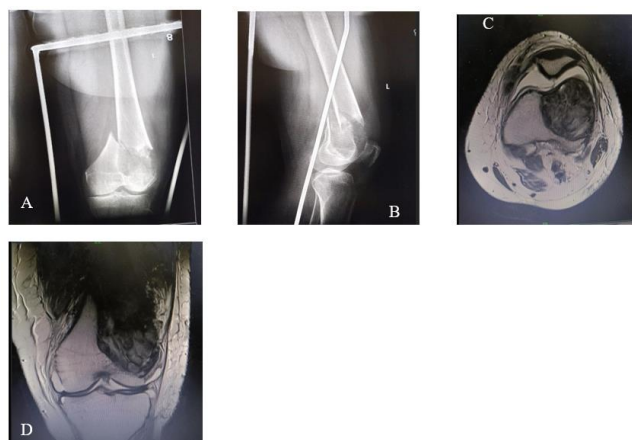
(A)&(B) Preoperative AP & Lateral X-rays showing well defined lytic shadow with fracture of the distal femur. (C) Axial and (D) coronal MRI sections showing involvement of lateral condyle with intact subchondral bone.
